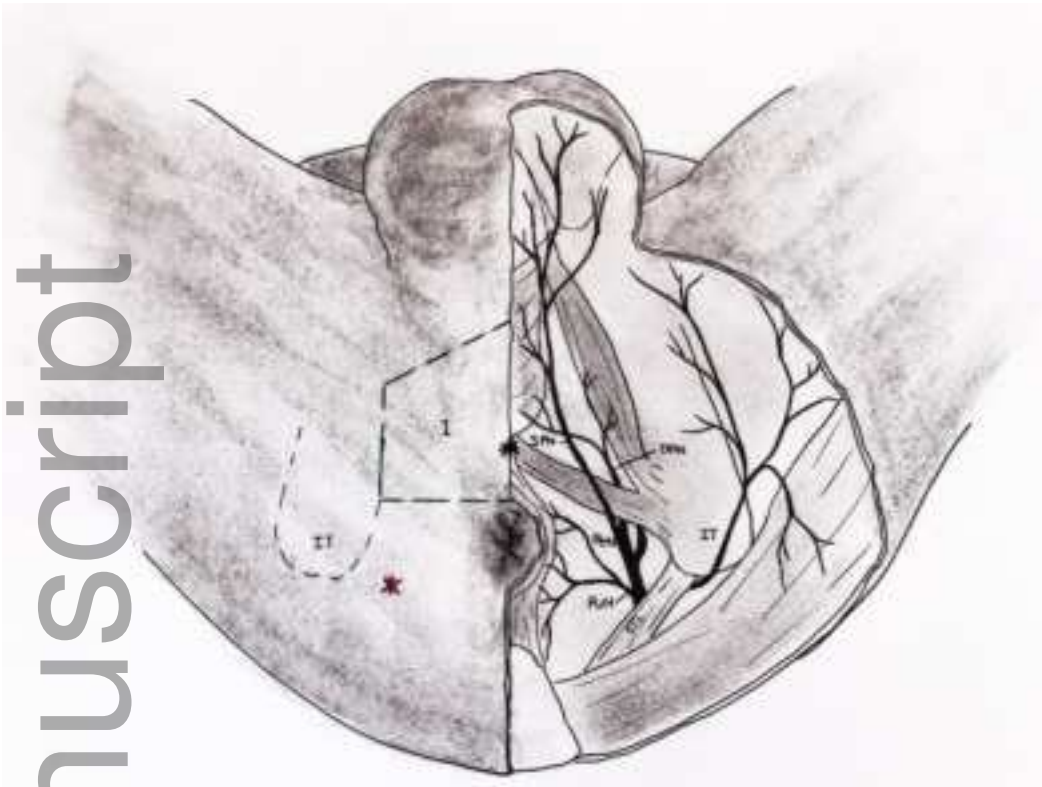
Periapical triangle.
